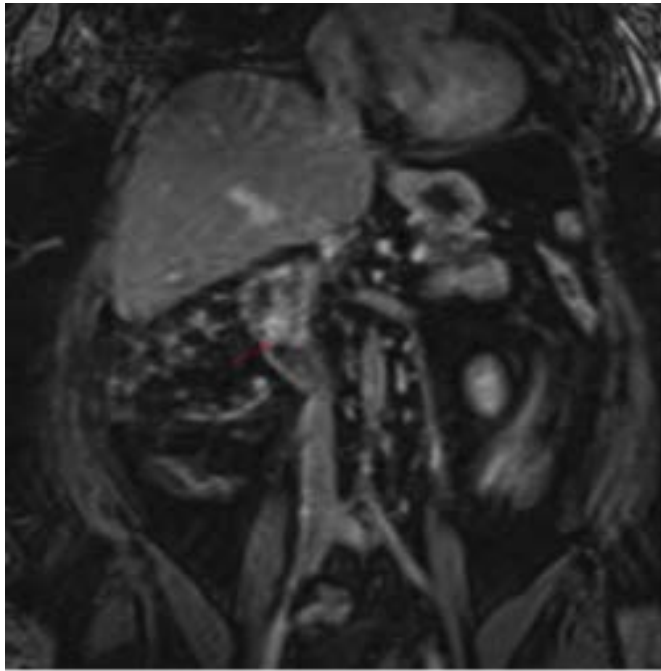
MRI of abdomen showing ampullary somatostatinoma (red arrow).
